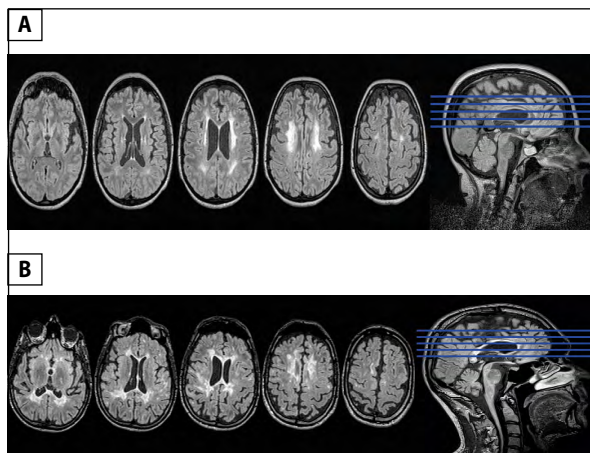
Examples of disseminated white matter lesions on MRI-FLAIR images in patients with clinically established systemic lupus erythematosus (A) and multiple sclerosis (B)
